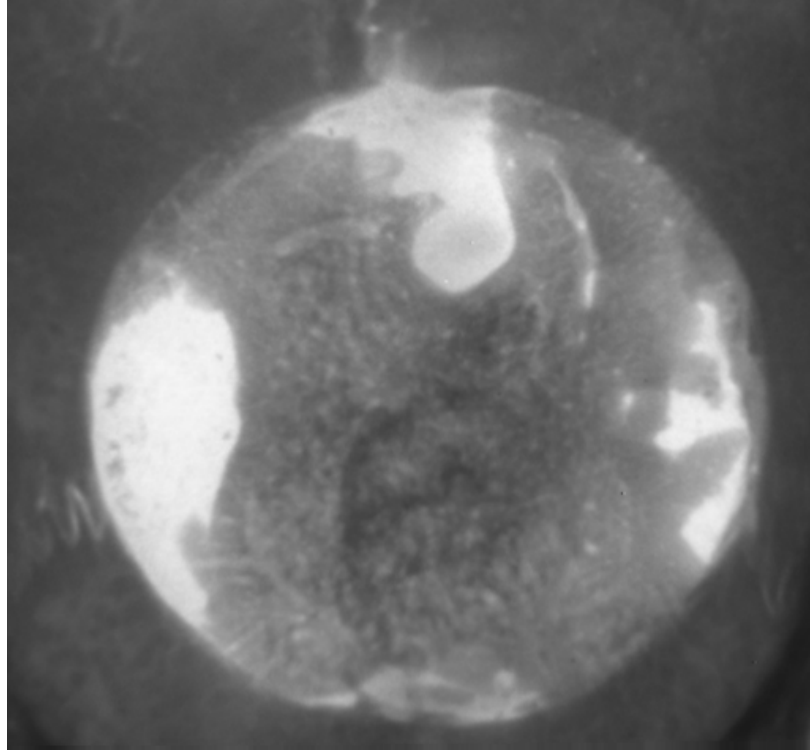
Micro CT image of DuraGen® + BMP / positive control at 4 weeks
